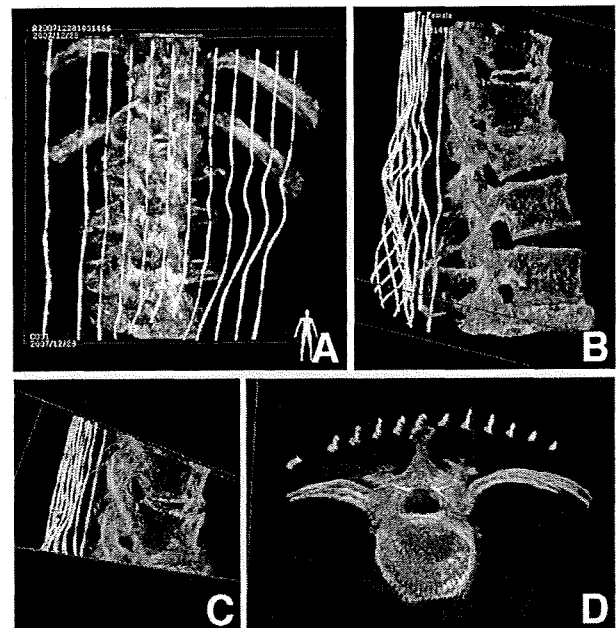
Three-dimensional radiographs after attaching a marker to the back of the patient. A: Anteroposterior view; B: lateral view; C: lateral view, including the plane passing through the lamina, pedicle, and body of the vertebrae; D: axial view.
